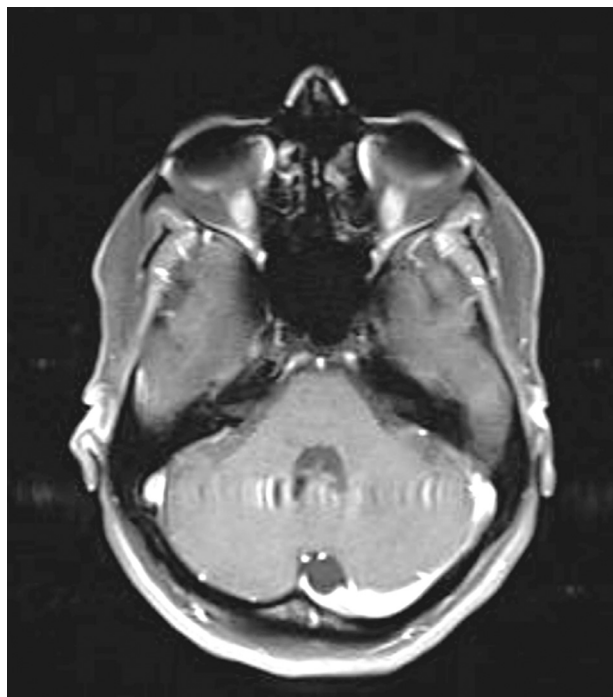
Brain MRI T1 axial view postcontrast. Post contrast images showed no pathological enhancement.
